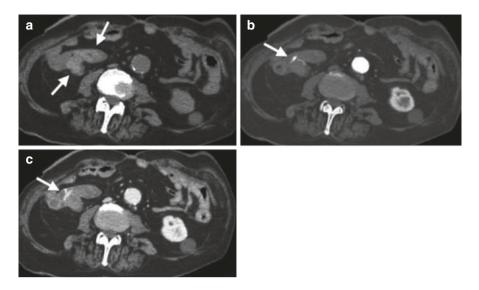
(a) Axial unenhanced CTA image shows intraluminal hyperattenuation (arrows). (b, c) Axial arterial phase (b) and portal venous phase (c) CTA images show an intraluminal jet (arrow) of contrast material in the arterial phase, which changes in size and morphology in the portal venous phase. This represents an active GI bleed
